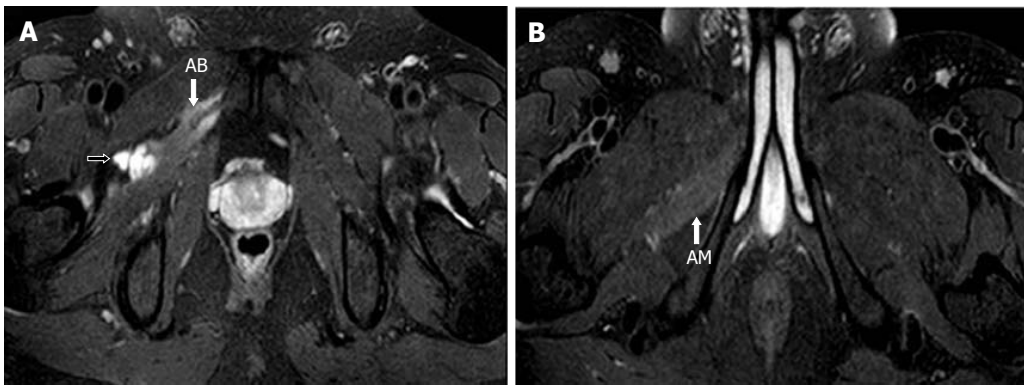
Image A, B show serial, T2-weighted fat suppressed axial images of the pelvis that demonstrates the further inferior extension of the cyst along the anterior branch of the obturator nerve (black arrow). Note the denervation atrophy of adductor brevis (AB) and magnus (AM) muscles. Reprinted with permission from Acta Neurologica Belgica.
